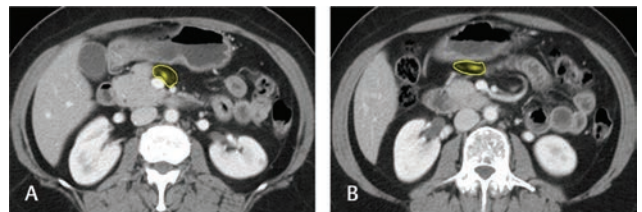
Stations 14 to 15. Axial computed tomography depicts the location of station 14v (A) along superior mesenteric vein and station 15 (B) along middle colic vessels.
